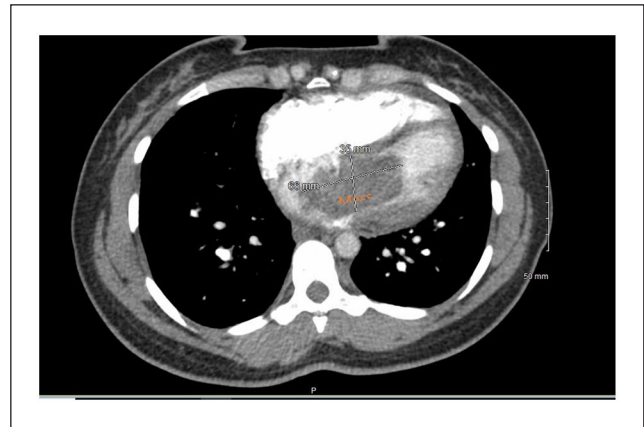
CT angiogram of the chest demonstrated a large intracardiac mass.
